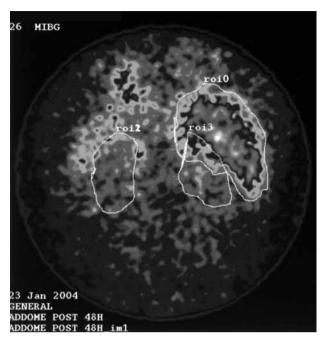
MIBG scintigraphy reveals ipercaptation by left adrenal medulla.
